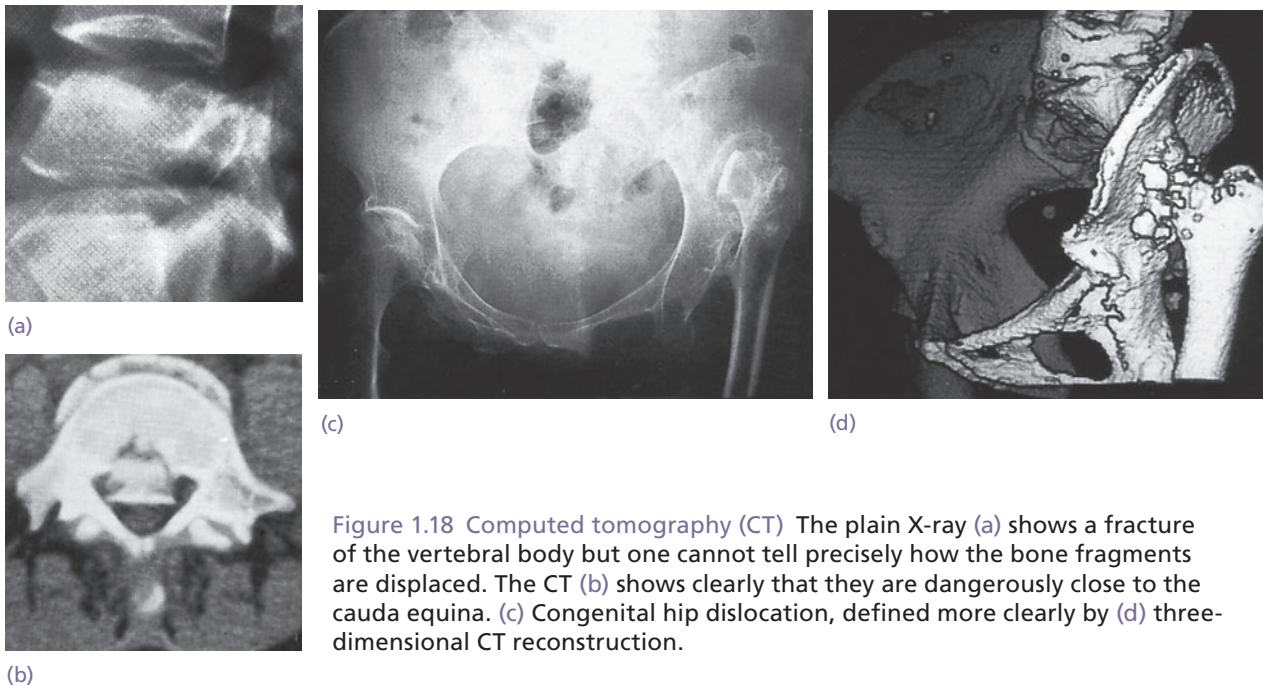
Computed tomography (CT) The plain X-ray (a) shows a fracture of the vertebral body but one cannot tell precisely how the bone fragments are displaced. The CT (b) shows clearly that they are dangerously close to the cauda equina. (c) Congenital hip dislocation, defined more clearly by (d) three-dimensional CT reconstruction.
